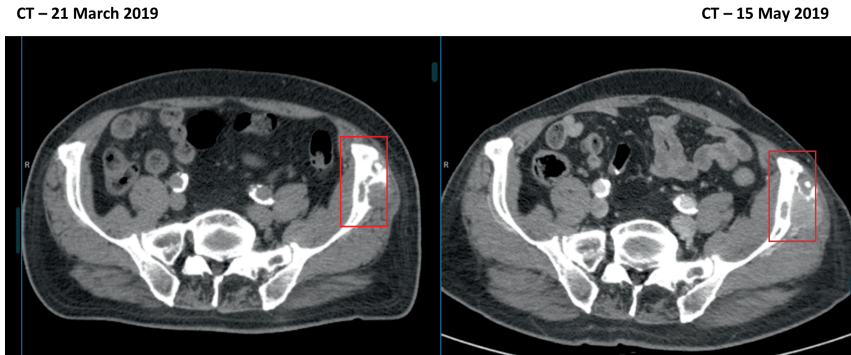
S2: The osteolytic progress of the lesion between 2 CT scans, leading to local changes close by and in the pelvis bone. The lesion is indicated by a red square. The CT scan acquired in May was contrast-enhanced.
